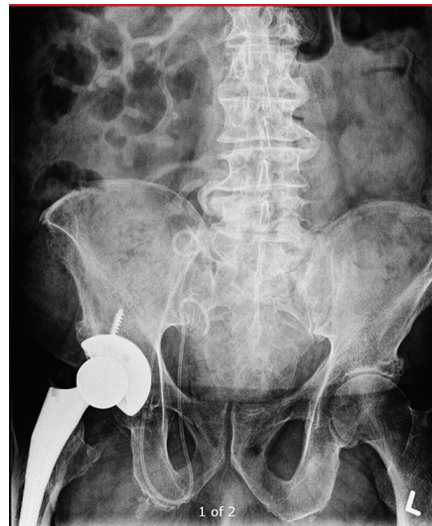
X-ray of kidney-ureter-bladder showing no residual fragments and the proximally migrated double-J ureteric stent along the course of the ureter in the ureteroinguinal hernia.
